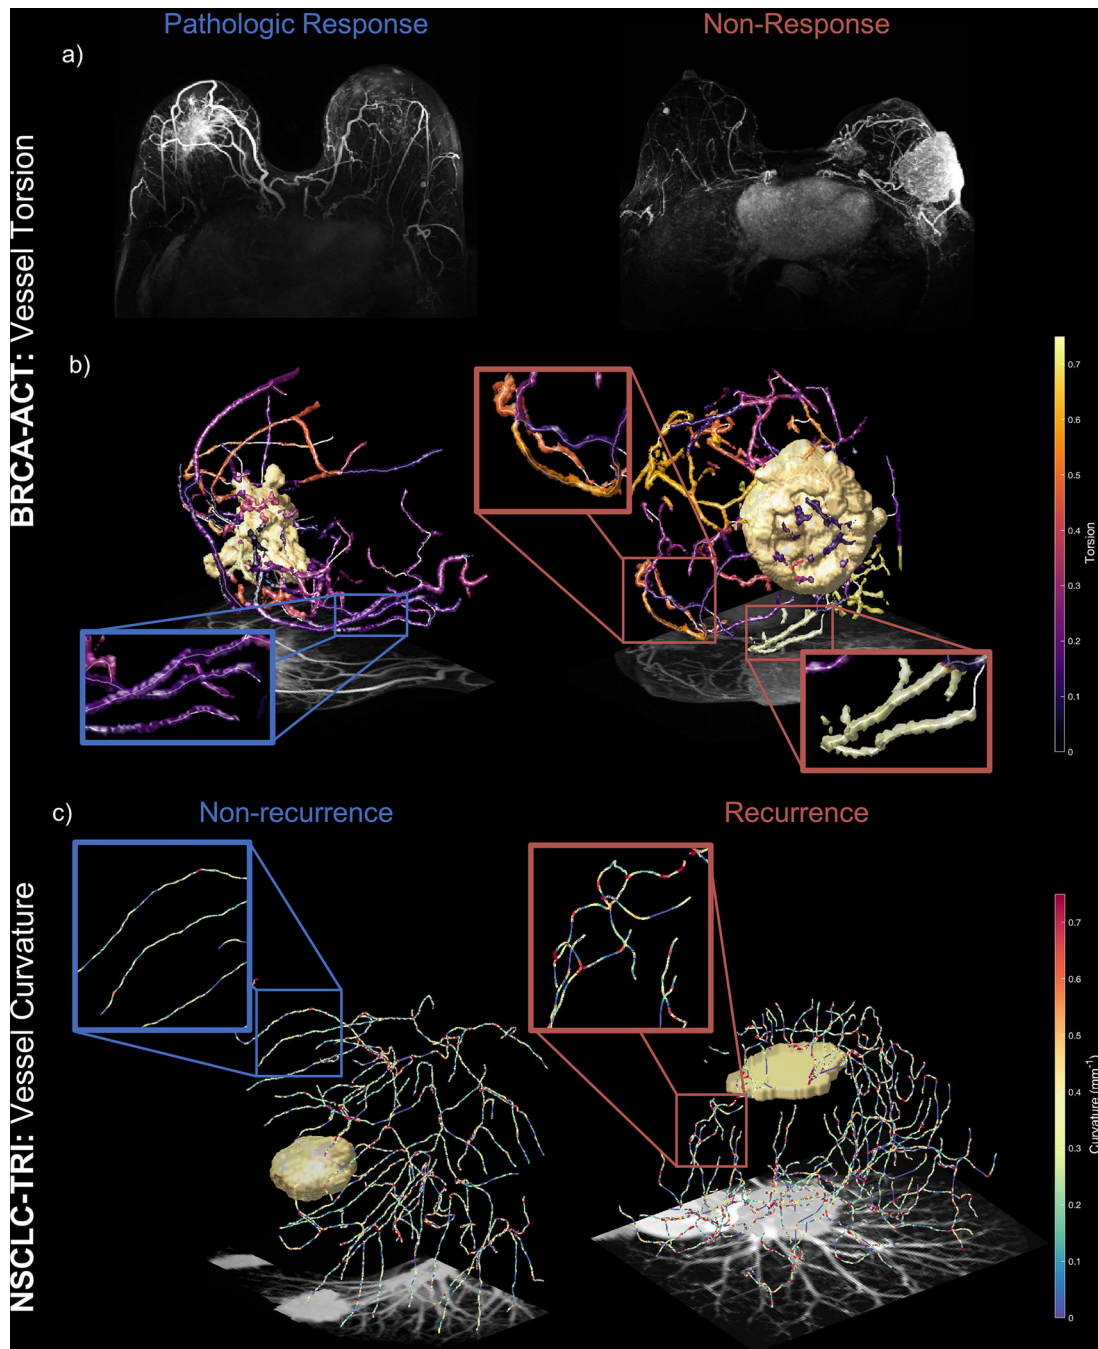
QuanTAV morphology measures detect differences in vessel shape on pre-treatment breast MRI and lung CT predictive of outcome following treatment including chemotherapy. Top: Elevated vessel torsion is associated with non-response to anthracycline-based chemotherapy in breast cancer (BRCA-ACT). a) maximum intensity projections of pre-treatment DCE-MRI subtraction images for patients who did (left) and did not (right) experience pathologic response following BRCA-ACT. b) Vessel torsion on pre-treatment dynamic MRI distinguishes non-responders and complete responders. For each discrete
